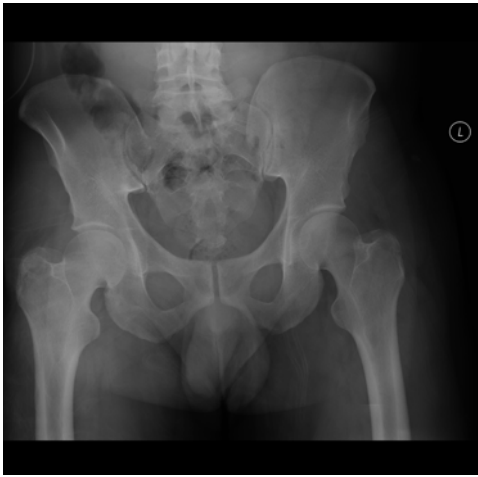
Radiograph of a normal pelvis.
